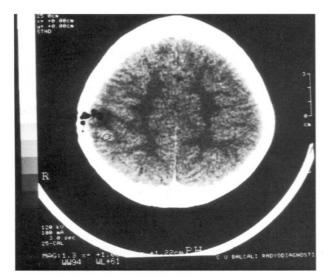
(Case 1): A Postoperative CT scan showing a right parietal intracranial air and area of small cerebral contusion.
